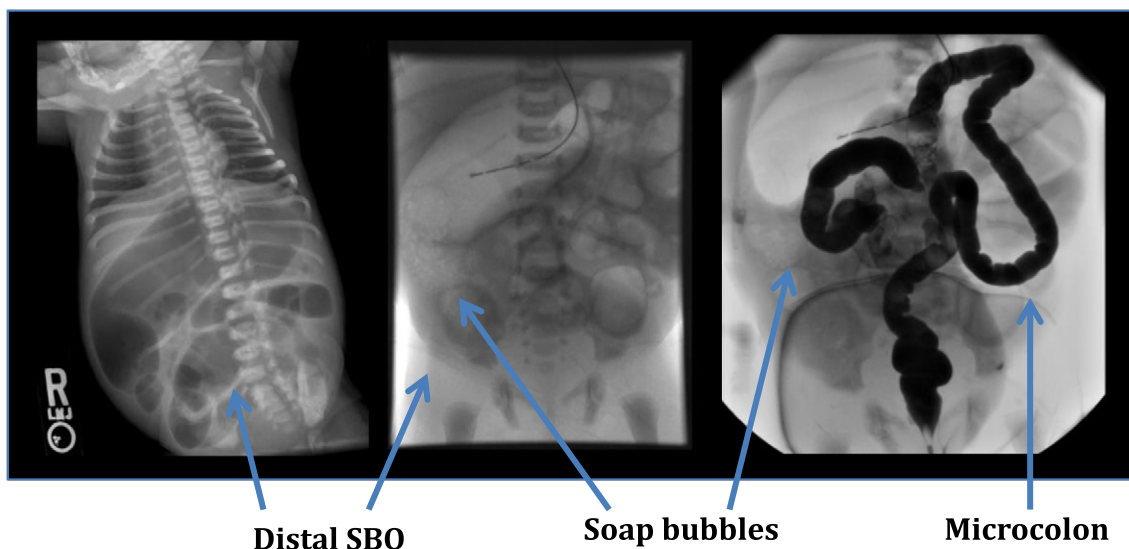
Plain film and contrast enema findings in MI. Images courtesy of Neil Fernandes MD, UTSW/Children's Health, Dallas, Texas.
